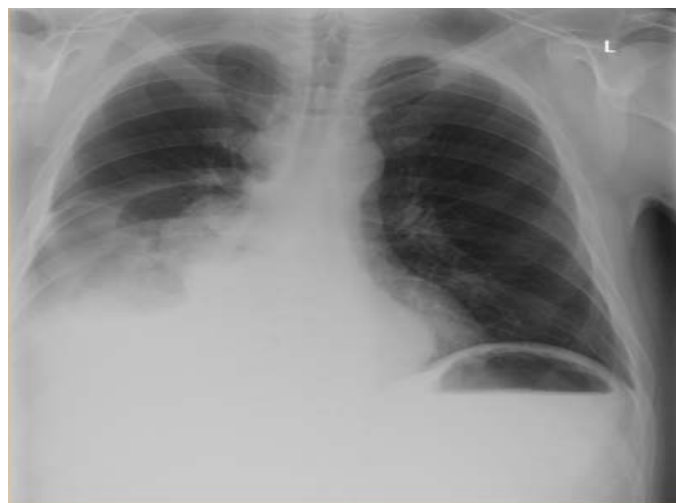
Control chest radiography
